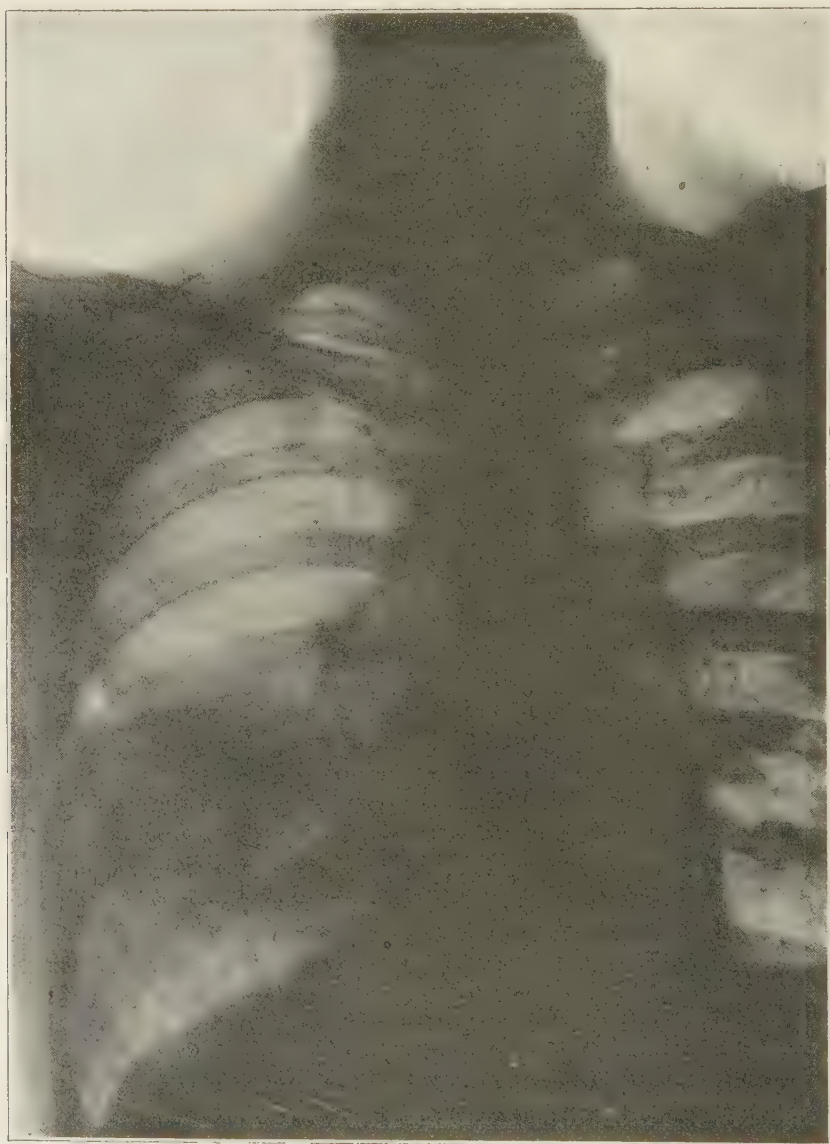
Radiograph of patient with pulmonary abscess in right base due to spirochetal infection.
